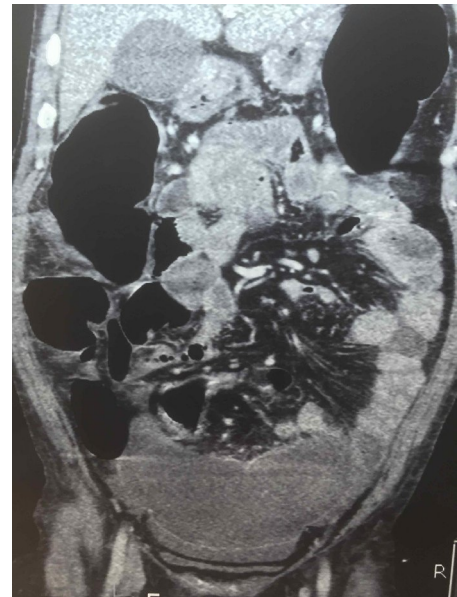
CT scan of the abdomen showing hugely dilated large intestine
